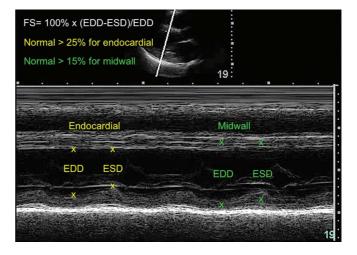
M-mode tracing from a parasternal long axis window showing calculation of fractional shortening.
